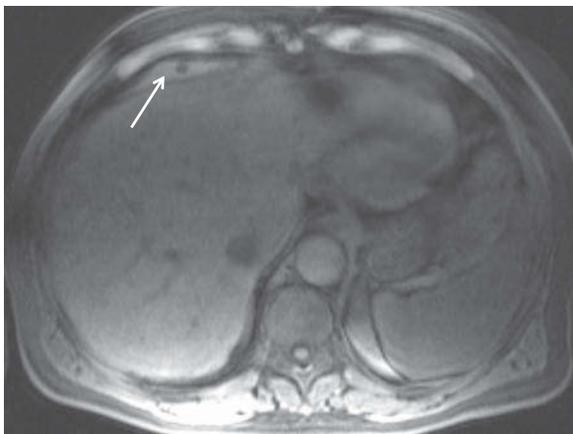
Cirrhotic liver with hemoperitoneum. Axial T1-weighted, fat-saturated pre-contrast image demonstrates a nodular cirrhotic liver with subcapsular, T1-bright material compatible with blood (arrow). Although a focal liver lesion was not definitively detected on post-contrast imaging, the radiologist should strongly suspect underlying HCC (which was later surgically confirmed).
